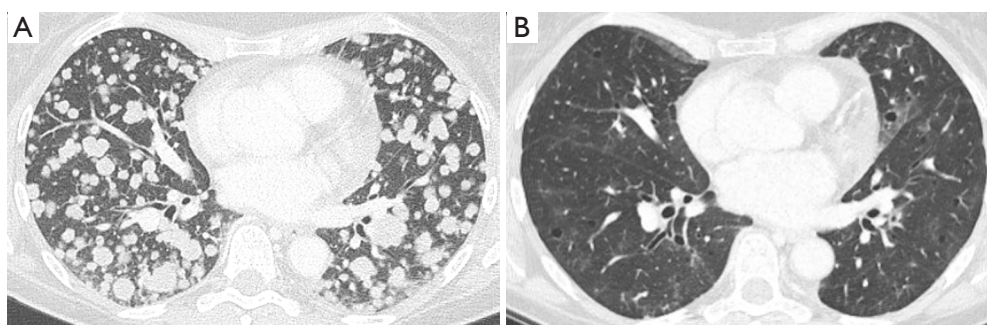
CT scans of case #2 performed before the initiation of the therapy with gefitinib (A) and after three months of treatment (B), showing CR. CT, computed tomography; CR, complete response.
